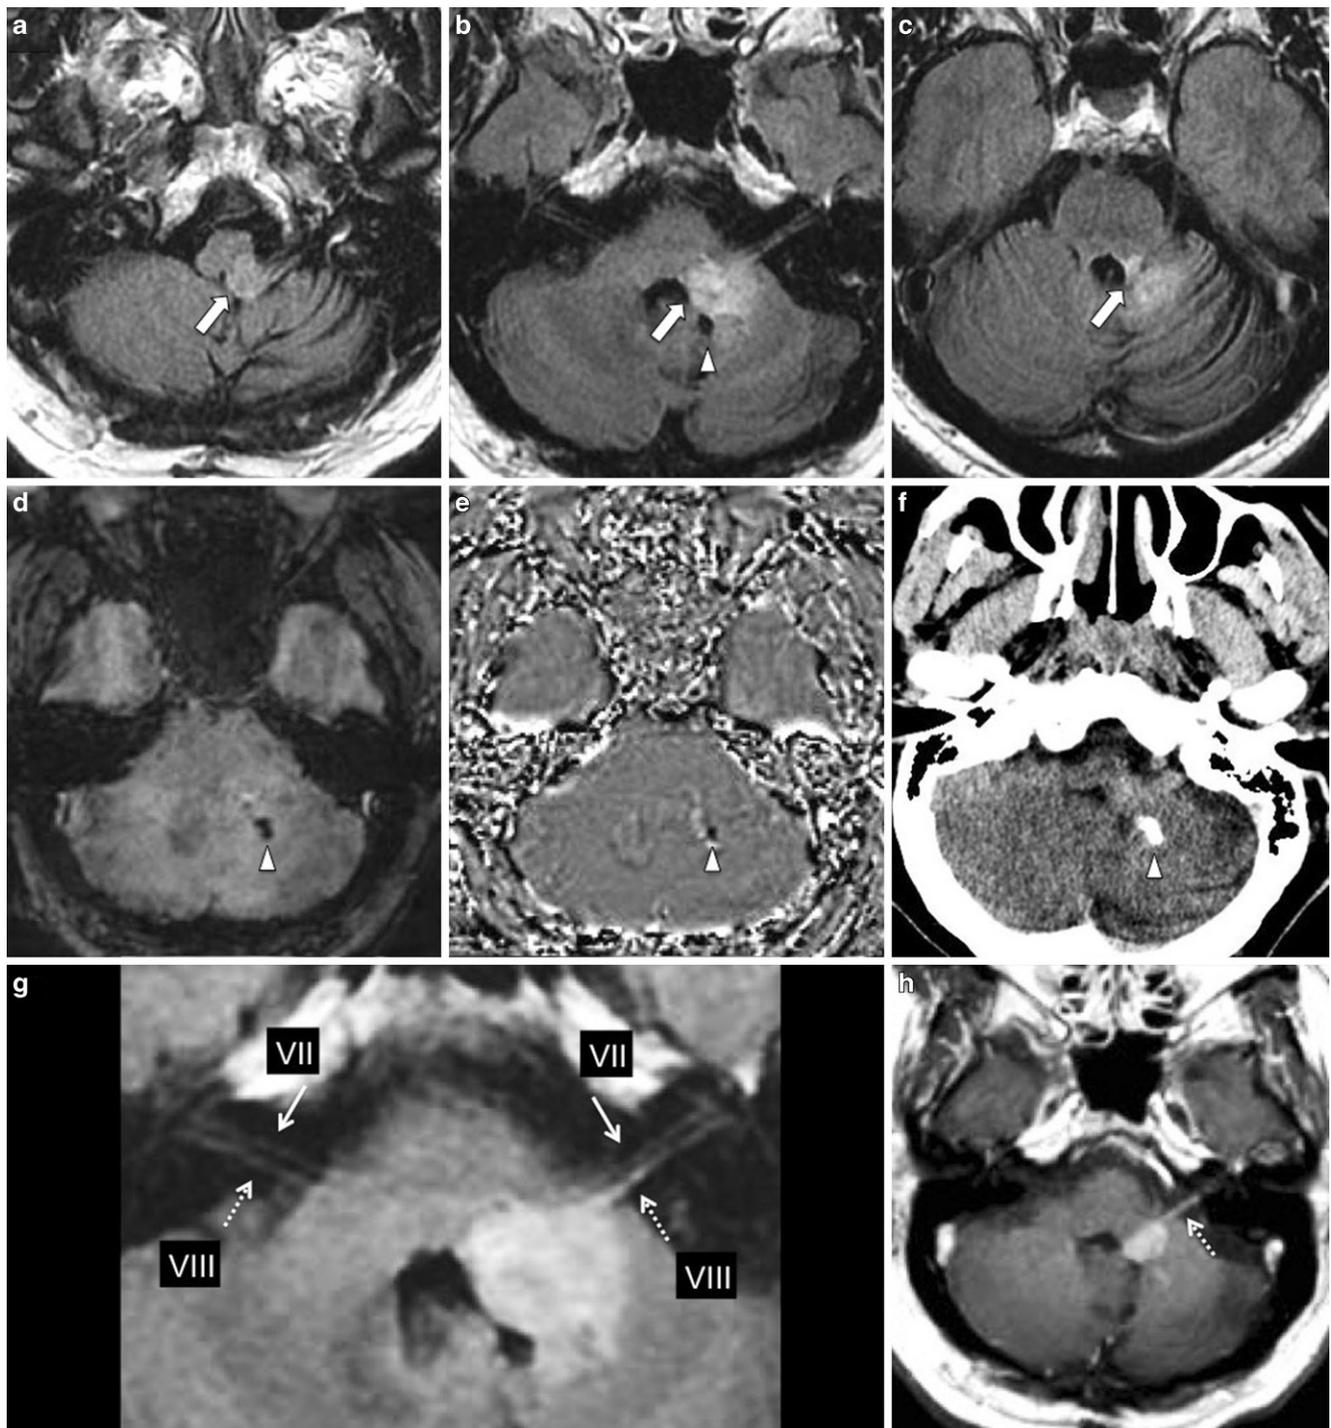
MRI brain axial FLAIR images (a–c) showing an expansile intra-axial lesion involving the left side of the brainstem, paramedian left cerebellar hemisphere and the left inferior, middle and superior cerebellar peduncle (*arrows*). An intralesional hypointense focus is evident (*arrowhead*) on the FLAIR image (b) which appears hypointense on both SWI and SWI phase images (d, e). Plain head CT (f) confirms presence of coarse intralesional calcification. Magnified FLAIR image (g) showed the left middle cerebellar peduncle mass at the level of the cerebellopontine angle with contiguous involvement of the cisternal segment of the left vestibulocochlear nerve over a distance of 10 mm (*dotted arrow*). Post-gadolinium-enhanced T1W image (h) demonstrates the enhancing left middle cerebellar peduncle mass and asymmetric thickening and enhancement of the left vestibulocochlear nerve (*dotted arrow*)
